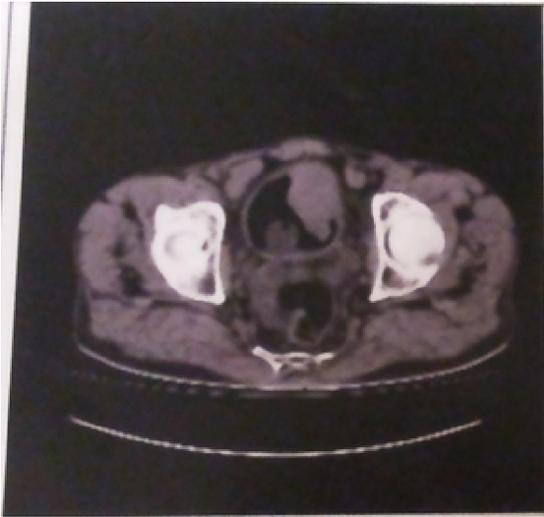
A: Axial CT images shows mass lesions on the left anterolateral aspect of the urinary bladder.
